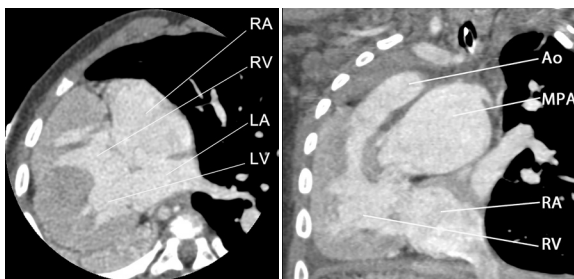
CT scan of 6-month old with Dextrocardia, Double Outlet Right Ventricle with atrioventricular canal and transposed great vessels s/p pulmonary arterial band (AO – Aorta, LA – left atrium, MPA – main pulmonary artery, LV – left ventricle, RA – right atrium, RV – right ventricle).
